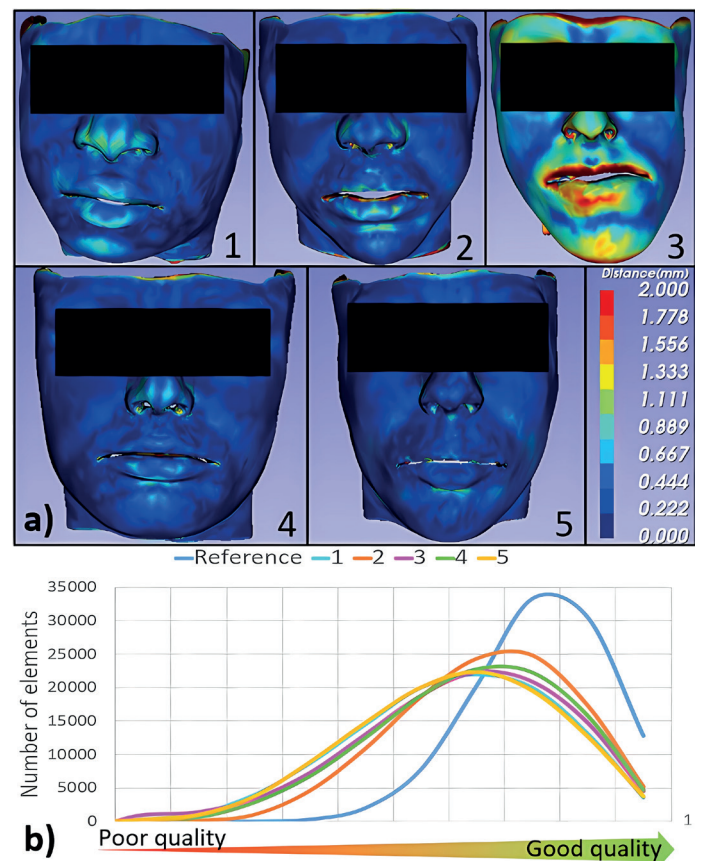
(a) Color map representing the discrepancies between the generated FE meshes of 5 patients and the actual external face geometry of these patients as reconstructed for their CT exams (mm); (b) Histograms of elements qualities in patient FE meshes, compared with the reference FE mesh.
